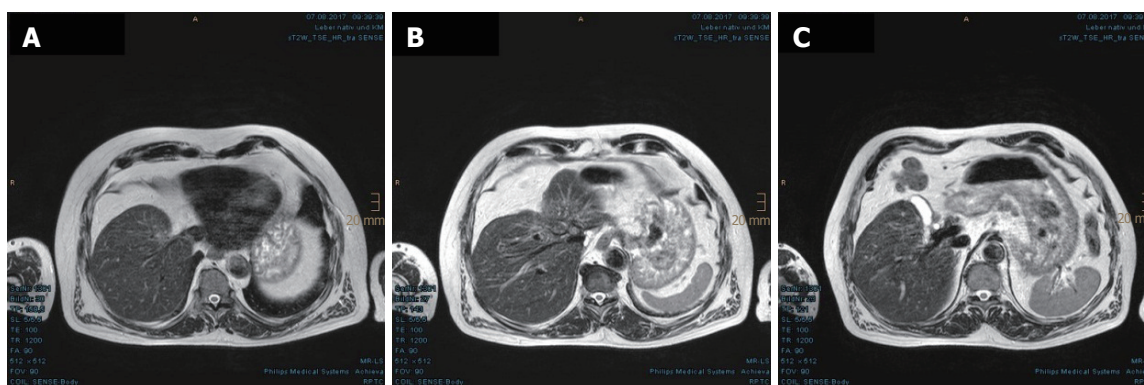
Residual nodules in the hepatic hilum without enhancement evidenced in the latest magnetic resonance imaging scan, at 40 mo after proton beam therapy. A: Complete regression of the upper portion of the hepatocellular carcinoma is shown; B: Pronounced indentation of the right-sided liver contour is shown, as if the patient had undergone a liver resection; C: The portal vein was able to be delimited again.
